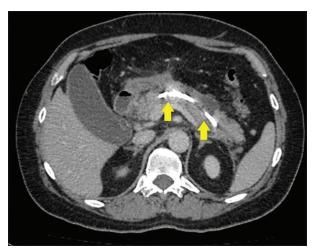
Computed tomography image after endoscopic transpapillary stent placement in the main pancreatic duct in patients with disconnected main pancreatic duct syndrome (stents in the main pancreatic duct and common hepatic duct are indicated by arrows). Adapted from [46]
